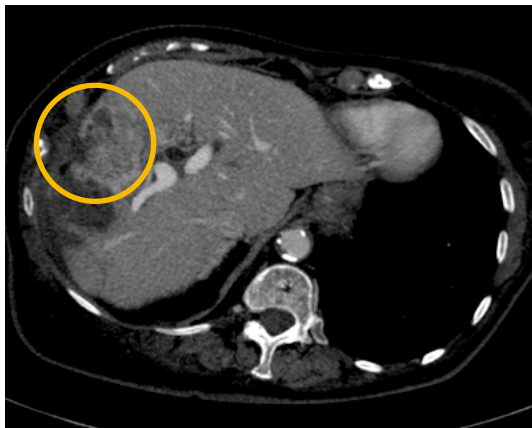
CT indicating partial response after second DSM-TACE at 3-month follow-up
